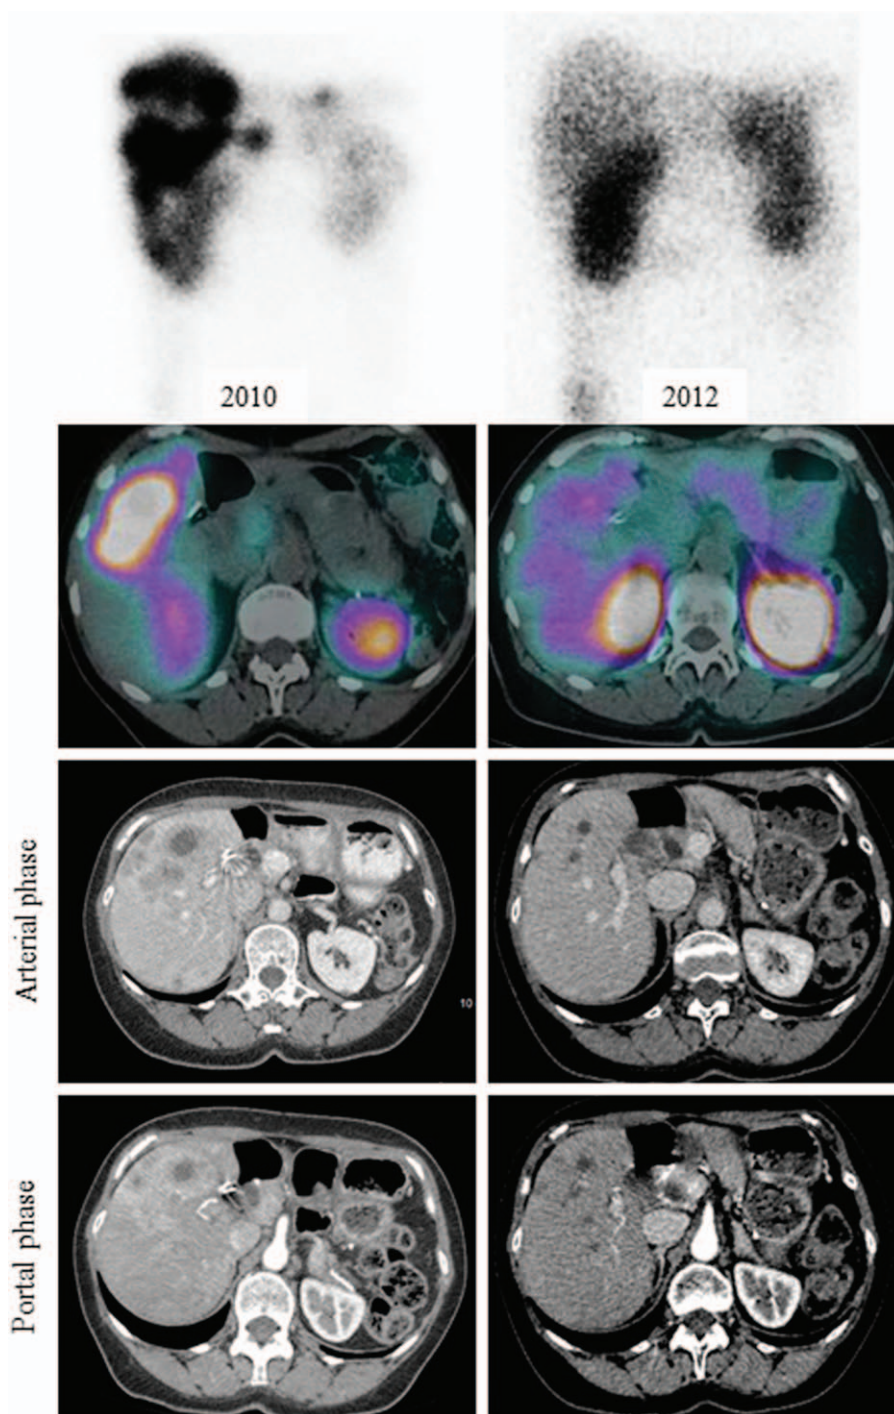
Complete remission of liver metastases after 4 cures of peptide receptor radionuclide therapy with ¹⁷⁷Lu DOTATATE confirmed on somatostatin receptor scintigraphy (OctreoScan) and computed tomography (CT) imaging. In the column on the left, note the high burden of liver metastases overexpressing SSTR2, with a high score of tumor uptake (grade 3 fixation) on OctreoScan. CT shows an enhanced contrast uptake during the arterial and portal time with diffuse liver damage. In the second column, complete remission of the metastases after 4 cures of ¹⁷⁷Lu DOTATATE with a consequent persistence of scars in the segment VIII, without contrast uptake on CT imaging and no fixation on OctreoScan.
